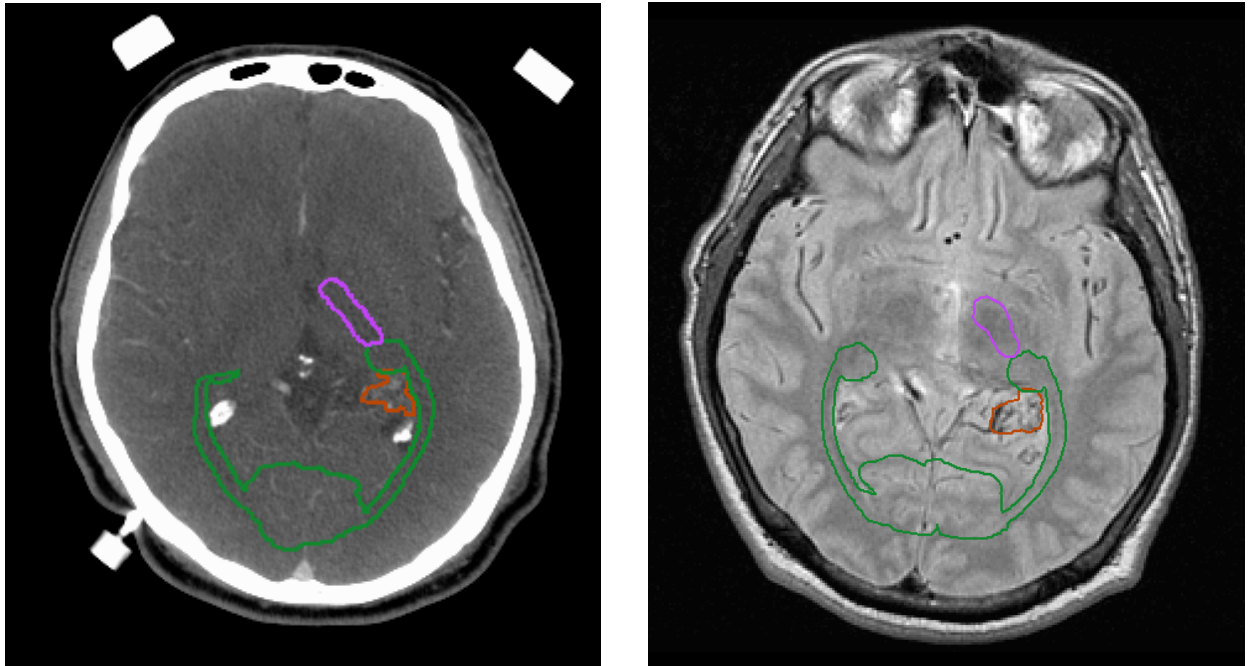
The target (PTV) and two critical structures, the optic pathway and the left motor strip, are shown as red, green and purple contours, respectively on: 1) CT slice and 2) MR slice. The contours are slightly different on two slices since the slices do not exactly coincide, due to different slice thicknesses in CT and MR images.
